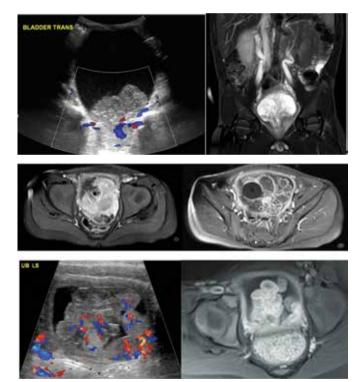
Embryonal rhabdomyosarcoma of the urinary bladder in children. (a) Color Doppler longitudinal section of the bladder shows a multilobulated mass with internal vascularity. (b-d) Mass is the base of the bladder. (e) similar lesion in another patient. (f) the lobulated lesion has high signal intensity. 4
